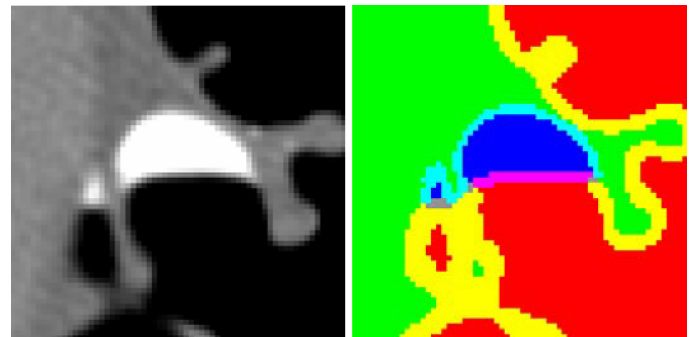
Resolution of the photovoltaic (PV) effect by our maximum a posteriori expectation-maximization (MAP-EM) mixture segmentation. (left) A zoomed-in view of a small region in a slice of a computed tomography (CT) volume image. (right) A zoomed-in view of the segmentation of the small region, with colors as follows. Red: Pure air space. Blue: Pure tagged colonic materials (TMs). Pink/gray: The mixture space of air and TMs. Yellow: The mixture space of air and colonic tissues. Light blue: The mixture space of TMs and colonic tissues. These interface layers, which indicate the presence of the PV effect, are accurately identified.
